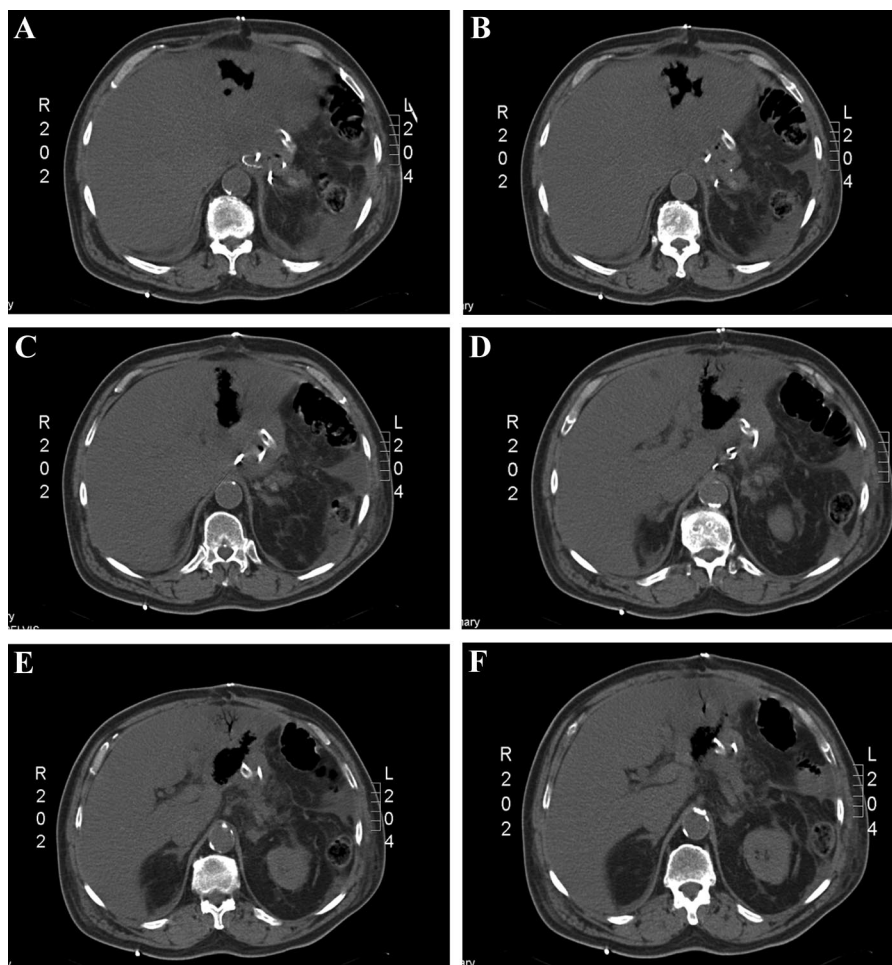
Sequential cephalad (a) to caudal (f) noncontrast CT scan images demonstrating destruction of the left lobe of the liver with free intraparenchymal gas. In addition to a large loculus of gas, a branching linear pattern of gas with the portal radicals is seen clearly (e). Also note the absence of spleen, absence of any localized collections, inflammatory stranding in left subhepatic space along the drain placed towards the hiatus.
